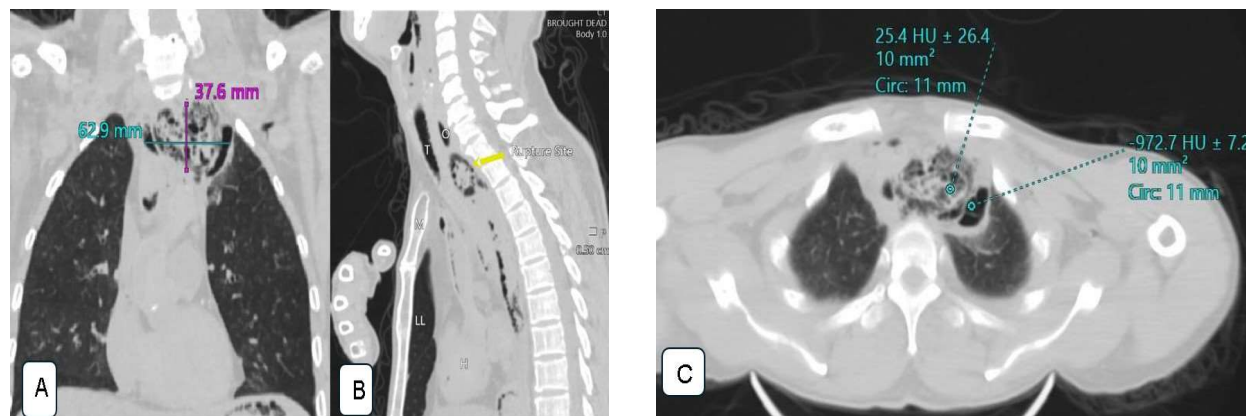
Postmortem computed tomography findings, (A) Coronal section of PMCT showing periesophageal densification by heterogeneous content measuring $62.9\text{mm} \times 37.6\text{mm}$ (Figure 1A) in the upper left superior mediastinum, (B) Sagittal section showing the rupture site above the line of Ludwig with infiltration in surrounding (marked with yellow arrow), with anatomical landmark i.e. M- Manubrium, LL- Left Lung, T-Trachea, O-Esophagus and H-Heart, (C) Axial section showing pneumomediastinum with Hounsfield value (HU) values ranging from +25 to -972, consistent with mediastinal contamination due to esophageal rupture
